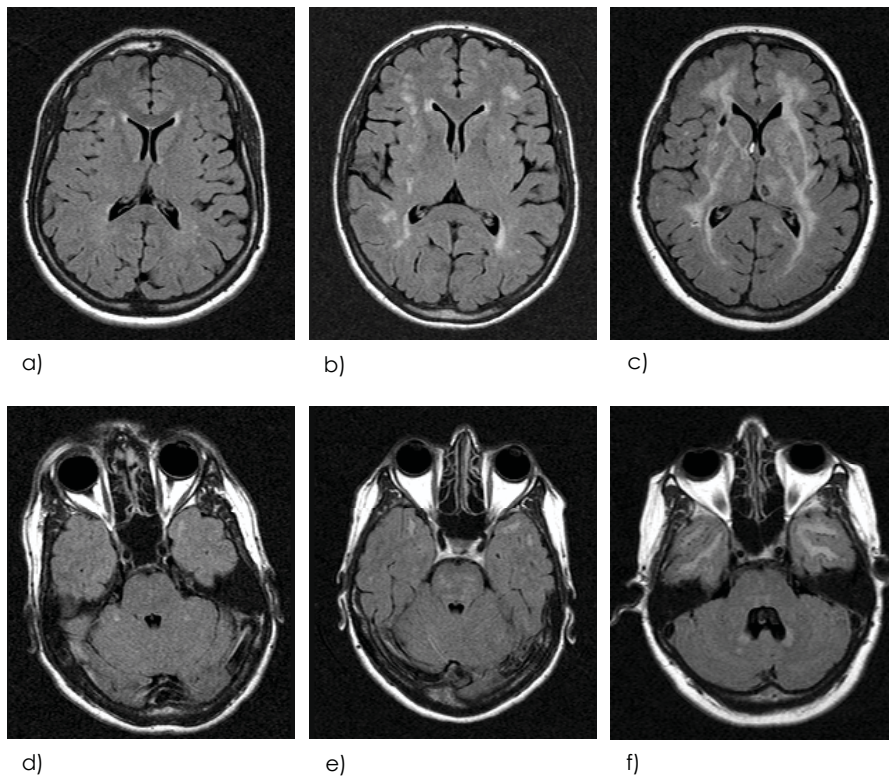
FLAIR MR images of three mutation carriers aged 26, 46 and 53 years. Axial slices through the level of the temporal lobes and basal ganglia showing the development of WMHs in the temporal lobe and external and internal capsule.
